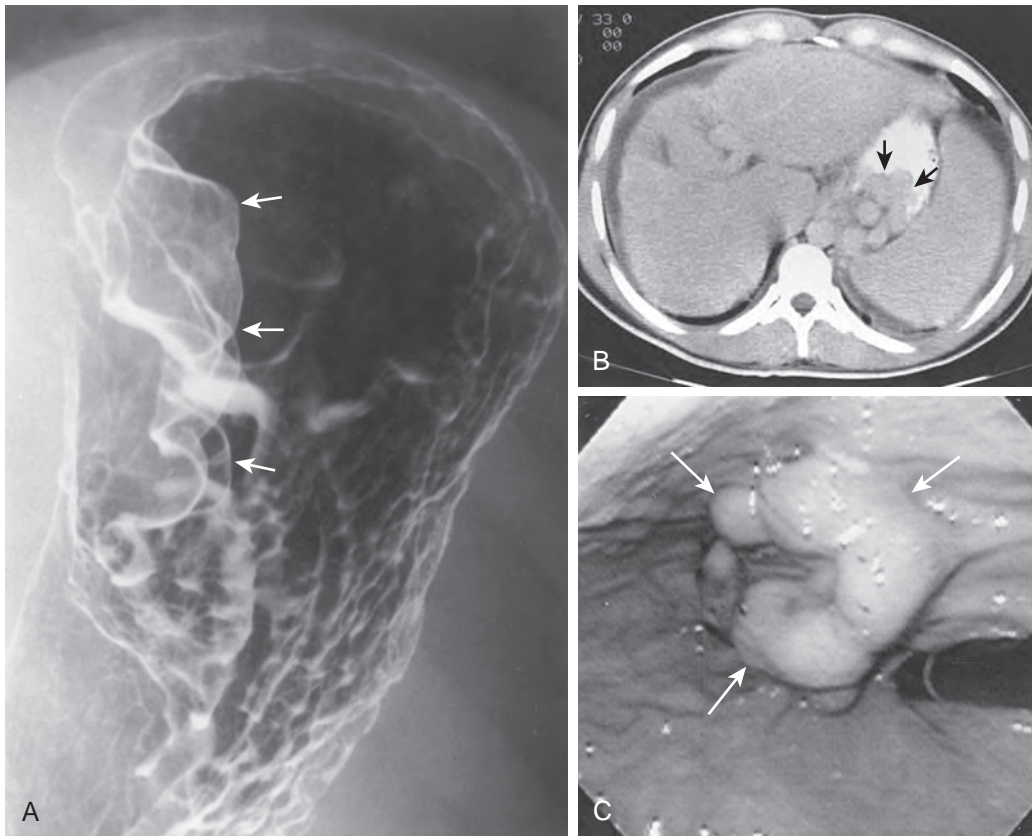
Conglomerate mass of gastric varices (also known as tumorous varices). A. Barium study shows a large, lobulated submucosal mass (arrows) on the medial aspect of the gastric fundus. Although this lesion could be mistaken for a malignant GI stromal tumor or even a polypoid carcinoma, note its smooth undulating contour. B. Unenhanced CT scan shows a lobulated soft tissue mass (arrows) on the posteromedial wall of the fundus. C. Endoscopic photograph shows a conglomerate mass of varices (arrows) in the gastric fundus adjacent to the cardia. This patient had underlying portal hypertension. (B and C from Levine MS, Kieu K, Rubesin SE, et al: Isolated gastric varices: Splenic vein obstruction or portal hypertension? *Gastrointest Radiol* 15:188–192, 1990.)
